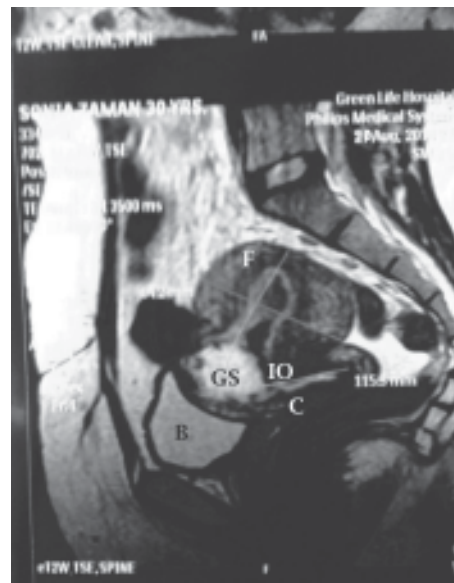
MRI shows a caesarean scar pregnancy just above the internal os with severe thinning of uterine wall at the anterior lower segment. (C-Cervix, GS-Gestational sac, IO- Internal os ,F- Fundus & B-Bladder)
